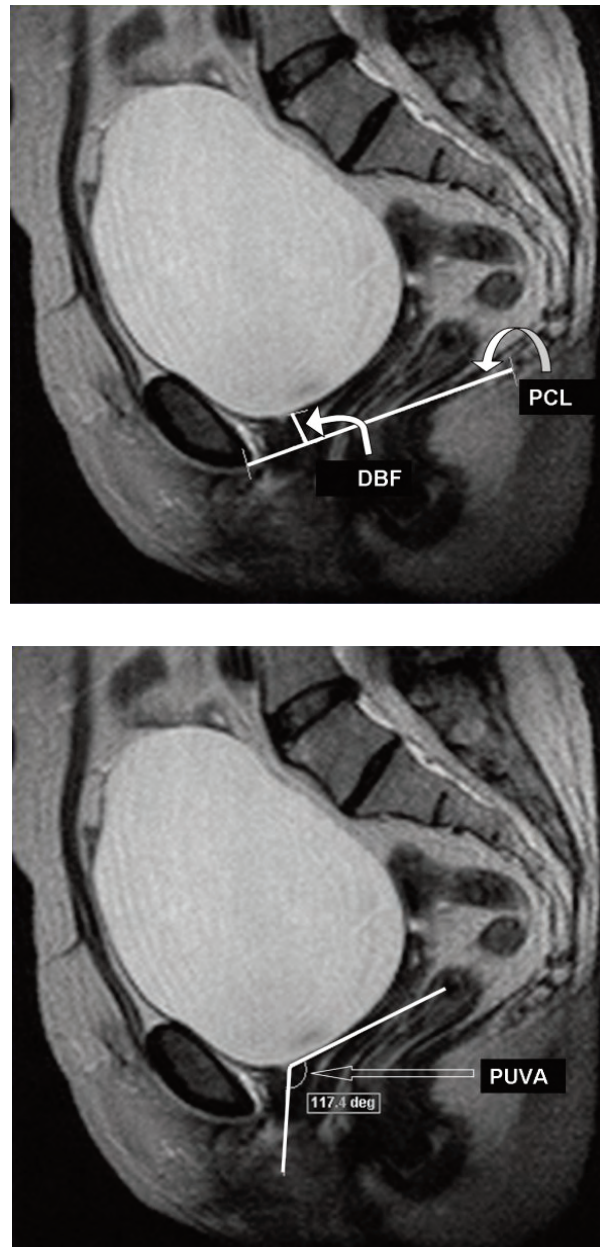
Sagittal T2-weighted MR images demonstrating the pubococcygeal line (PCL) and distance to the bladder floor (DBF) (A) and a posterior urethrovesical angle (PUVA)(B).
